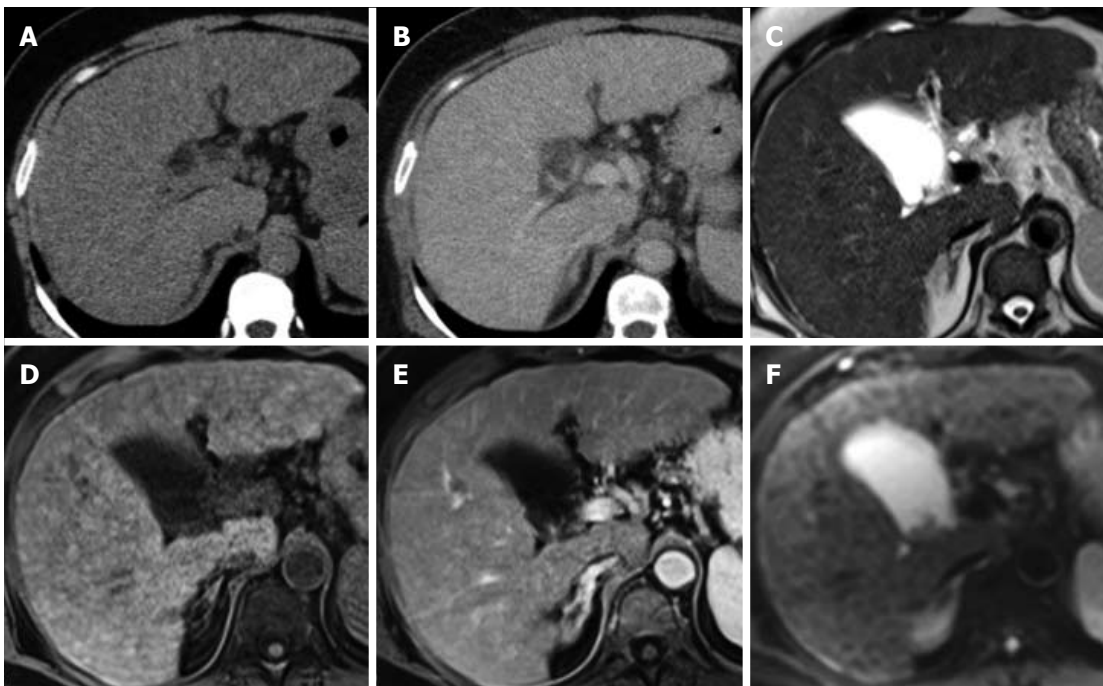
The liver demonstrates a nodular outline consistent with cirrhosis and multiple small regenerative nodules that are isodense on unenhanced (A) and portal venous phase (B) on computed tomography, predominantly isointense on T2W (C) and T1W (D) sequences with no evidence of arterial enhancement (E) or restricted diffusion (F).
